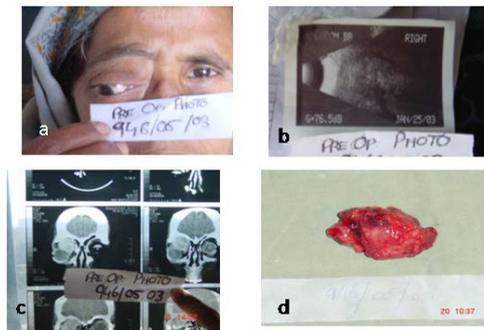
(a) Preoperative photo of a case of cavernous haemangioma of orbit; (b) B scan; (c) CT scan and (d) Tumour removed after lateral orbitotomy.
